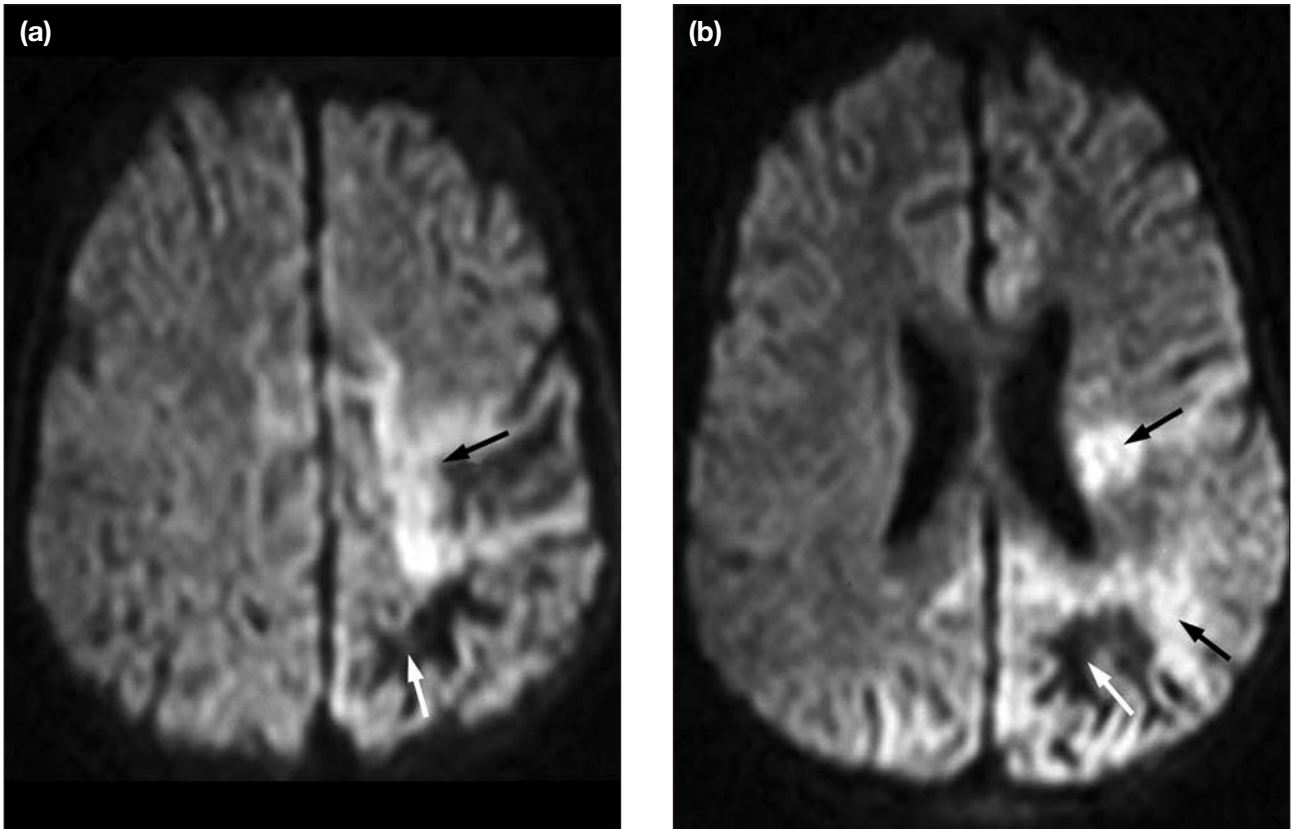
Diffusion-weighted magnetic resonance images of the brain at presentation showing focal bright areas of reduced diffusion in (a) the left centrum semiovale and (b) the corona radiata white matter indicating cytotoxic edema (black arrows). The white matter at the left parietooccipital region (white arrow) does not have restricted diffusion and corresponds to areas of tissue necrosis.
